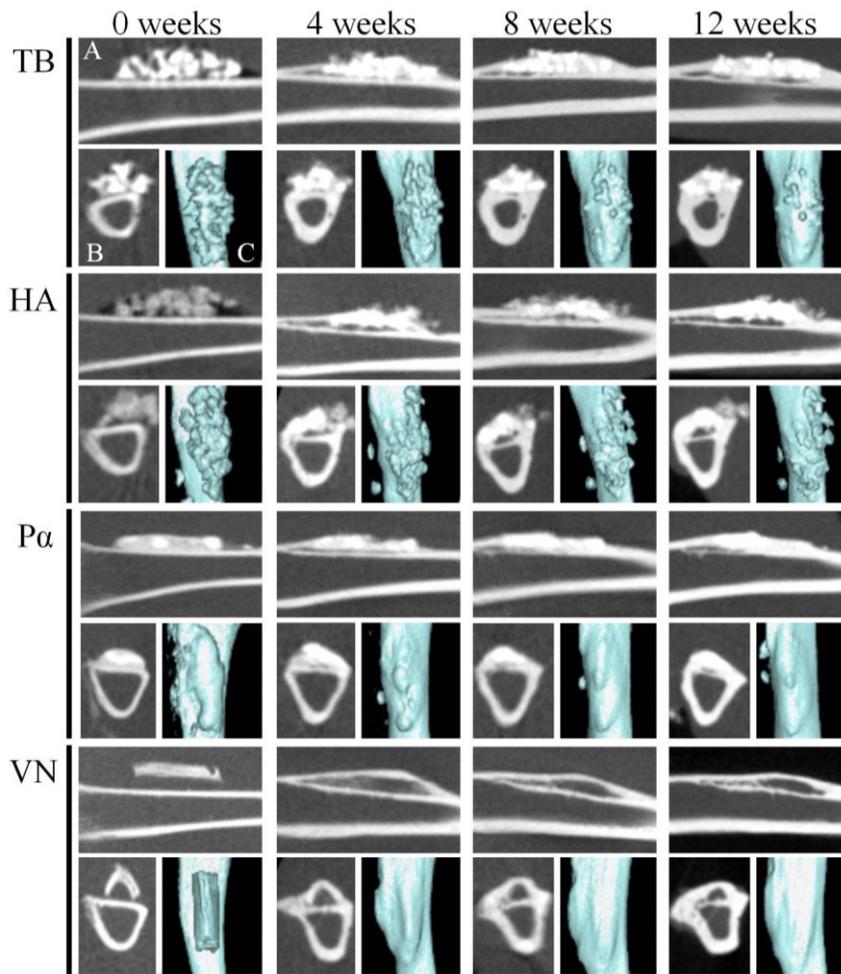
Representative sagittal plane (A), cross-sectional plane (B) and reconstructed 3D (C) CT images of bone graft sites. Newly formed bone (opaque images) extending to the cortical bone from both ends of each graft material is observed at 4 weeks after implantation.
